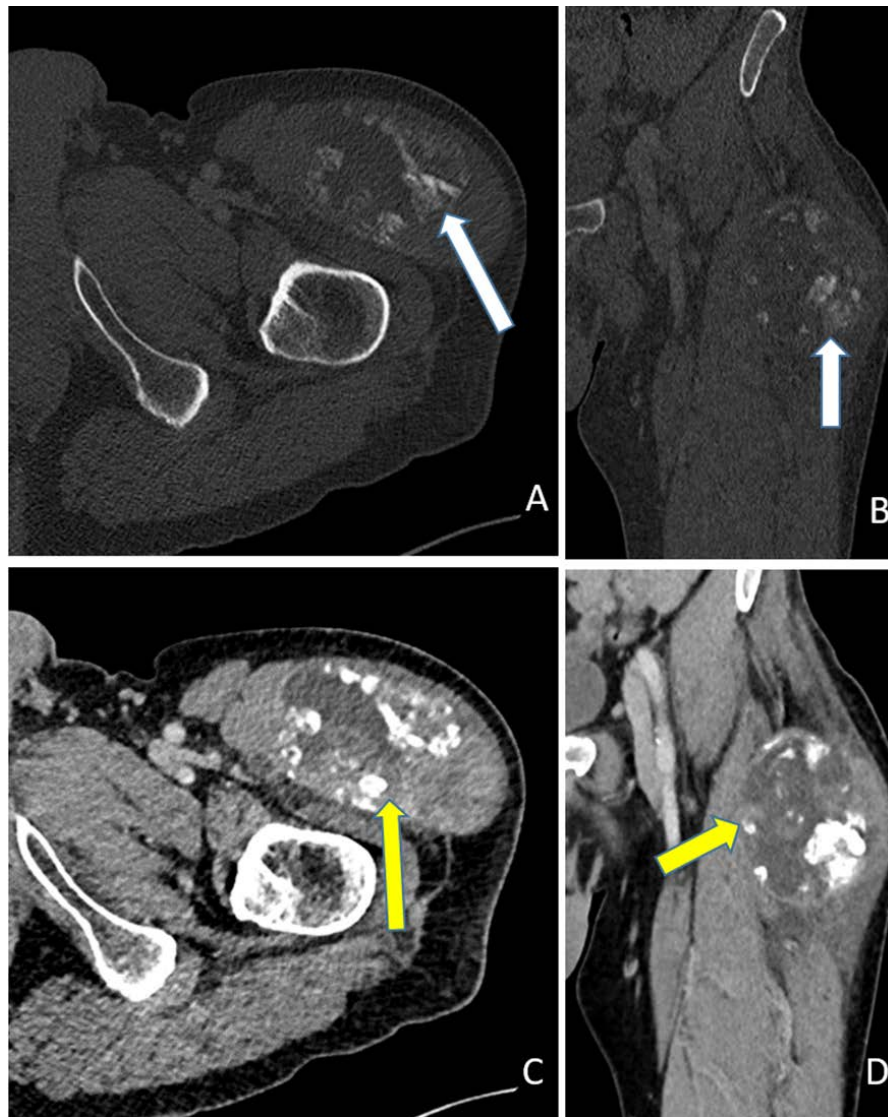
EOO in the left thigh (9.5 x 6.2 x 8.0 cm). A (axial), B (coronal): a large mass with peripheral mottled calcification (white arrows) could be seen on computer tomography (CT) images. C (axial), D (coronal): heterogeneous contrast enhancement (yellow arrows) can be observed on post-contrast CT images.
